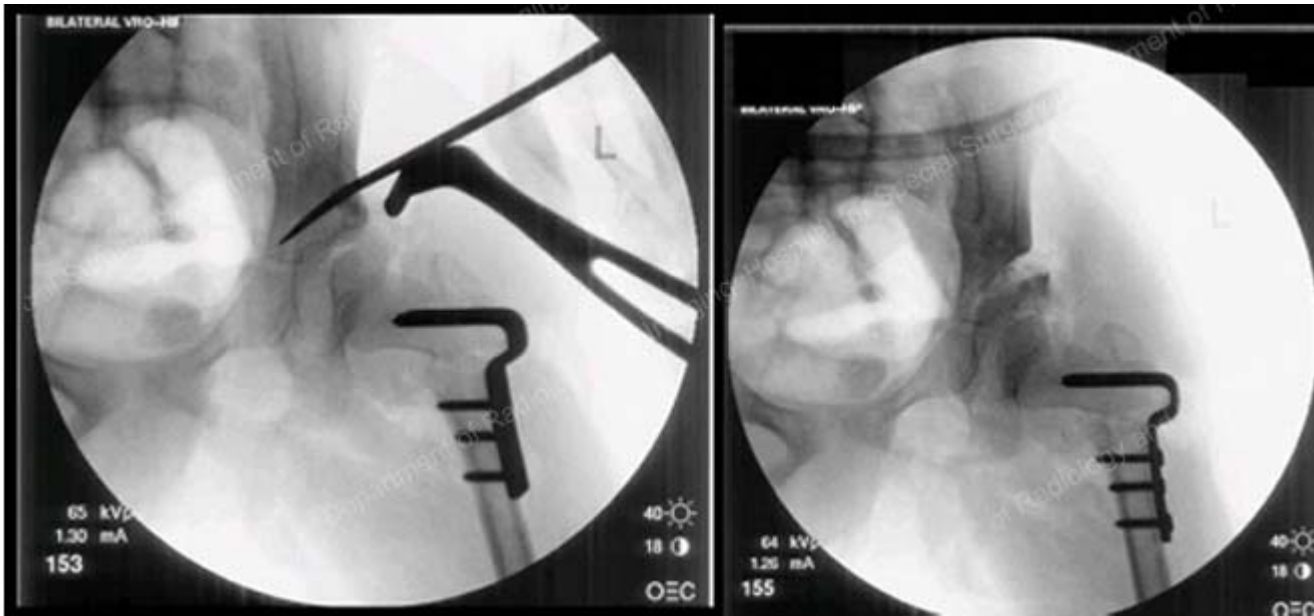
Intraoperative x-ray images obtained during a left VRO (varus rotational osteotomy) and pelvic osteotomy.
